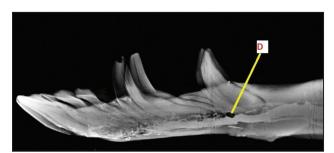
Lateral positive contrast radiograph showing opening of mandibular foramen into mental canal rostrally (D).
